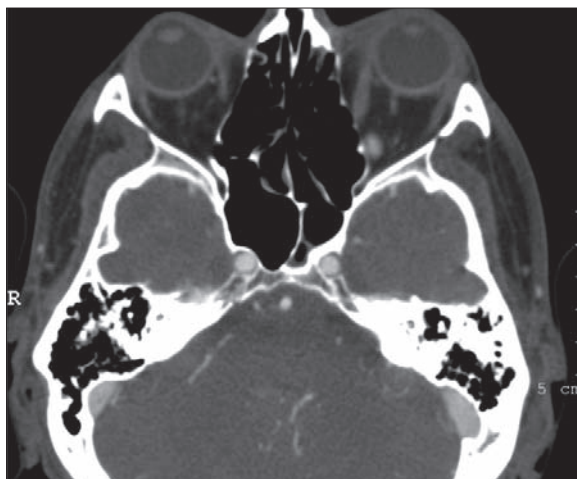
CT of the orbit. Lesion of hyperdensity, size: 8×5 mm, was affirmed in the upper-medial part of the left orbit after contrast medium application.
